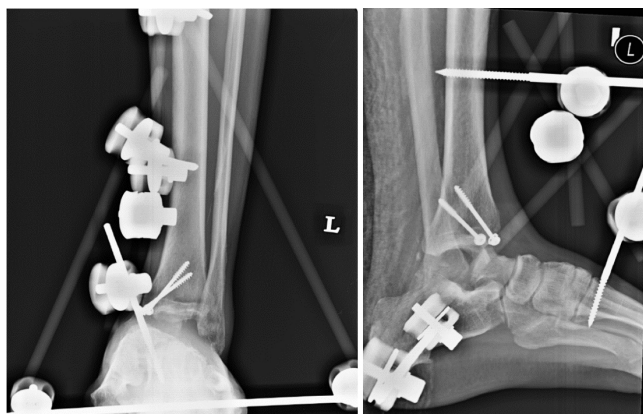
Anterior-posterior and lateral view radiographs of patient's left ankle after cross ankle fixation showing bone loss of the talus.
